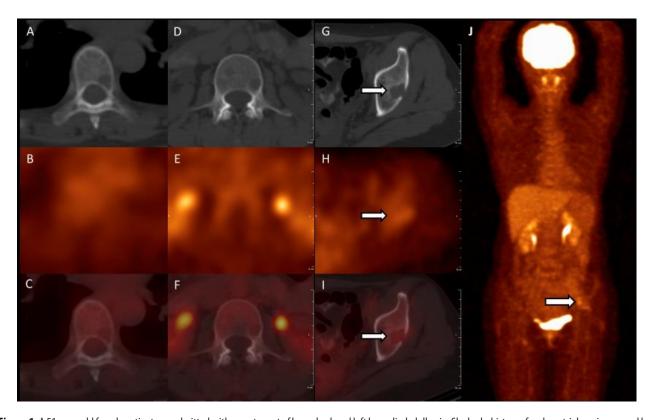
A 51-year-old female patient was admitted with recent onset of lower back and left lower limb dull pain. She had a history of endometrial carcinoma and had undergone hysterectomy and bilateral oophorectomy. On the computed tomography (CT) of the pelvis, multiple osteolytic lesions were detected in the lumbar spine and pelvic bones. Differential included multiple myeloma and metastatic malignancy. Patient was referred to ¹⁸F-FDG PET imaging for further evaluation. The axial images of thorax (A: CT, B: PET and C: fusion) and lumbar spine (D: CT, E: PET and F: fusion) showed multiple osteolytic bone lesions involving of the thoracic and lumbar vertebrates on CT, but there was no definitely increased ¹⁸F-FDG uptake on PET images. The maximum intensity projection (MIP) image (J) revealed only one mild increased ¹⁸F-FDG activity in the left iliac region (arrow) with a maximum standardize uptake value (SUVmax) of 3.2 (in comparison to the hepatic SUVmax of 3.1). On axial images (G: CT, H: PET and I: fusion), this activity corresponded to a lytic lesion (arrows). There was no other abnormality, which could be a primary lesion. The laboratory data including carcinoembryonic antigen (CEA), cancer antigen 125 (Ca 125), serum light chain and immunofixation electrophoresis, were within normal rangers.
